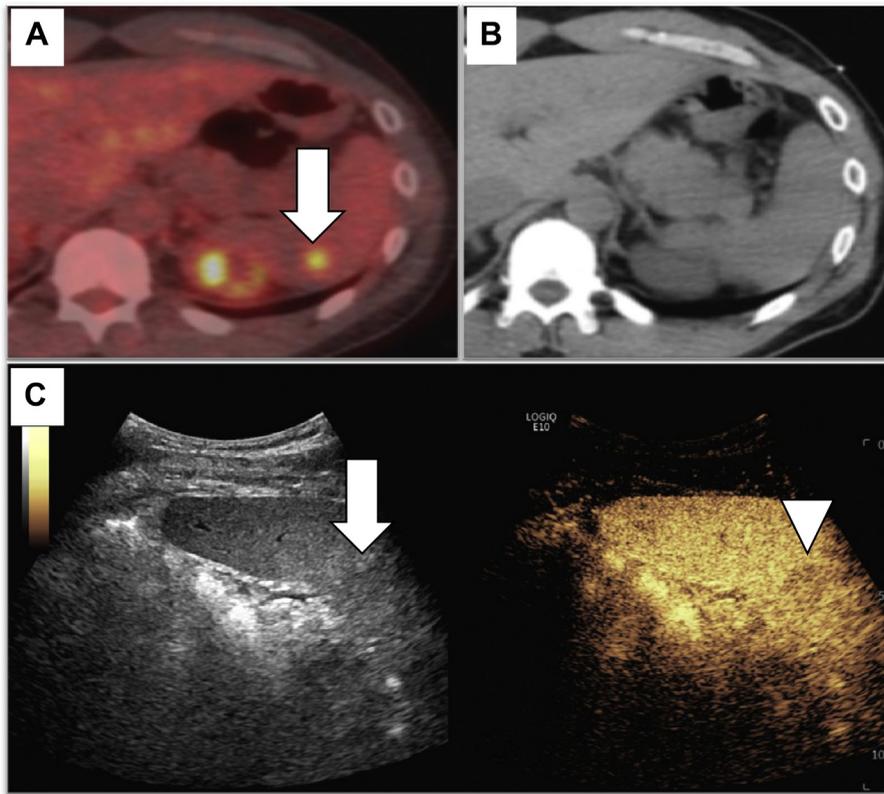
Percutaneous splenic biopsy in a 38-year-old man with a prior history of diffuse large B-cell lymphoma, who now presents with new splenic lesions on noncontrast PET/CT (A, arrow). As the lesions were small and difficult to visualize by noncontrast CT (B), the percutaneous biopsy was performed under US guidance. Although the small lesions proved isoechoic on gray-scale B-mode US (C, arrow), the application of CEUS enabled visualization (C, arrowhead).
